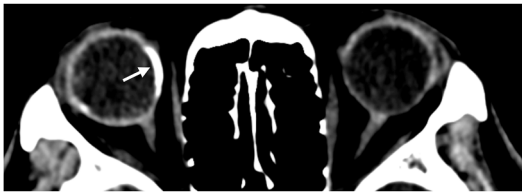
Axial CT showing scleral calcifications in patient with prior right eye cytomegalovirus retinitis on a background of retroviral disease (*white arrow*).
